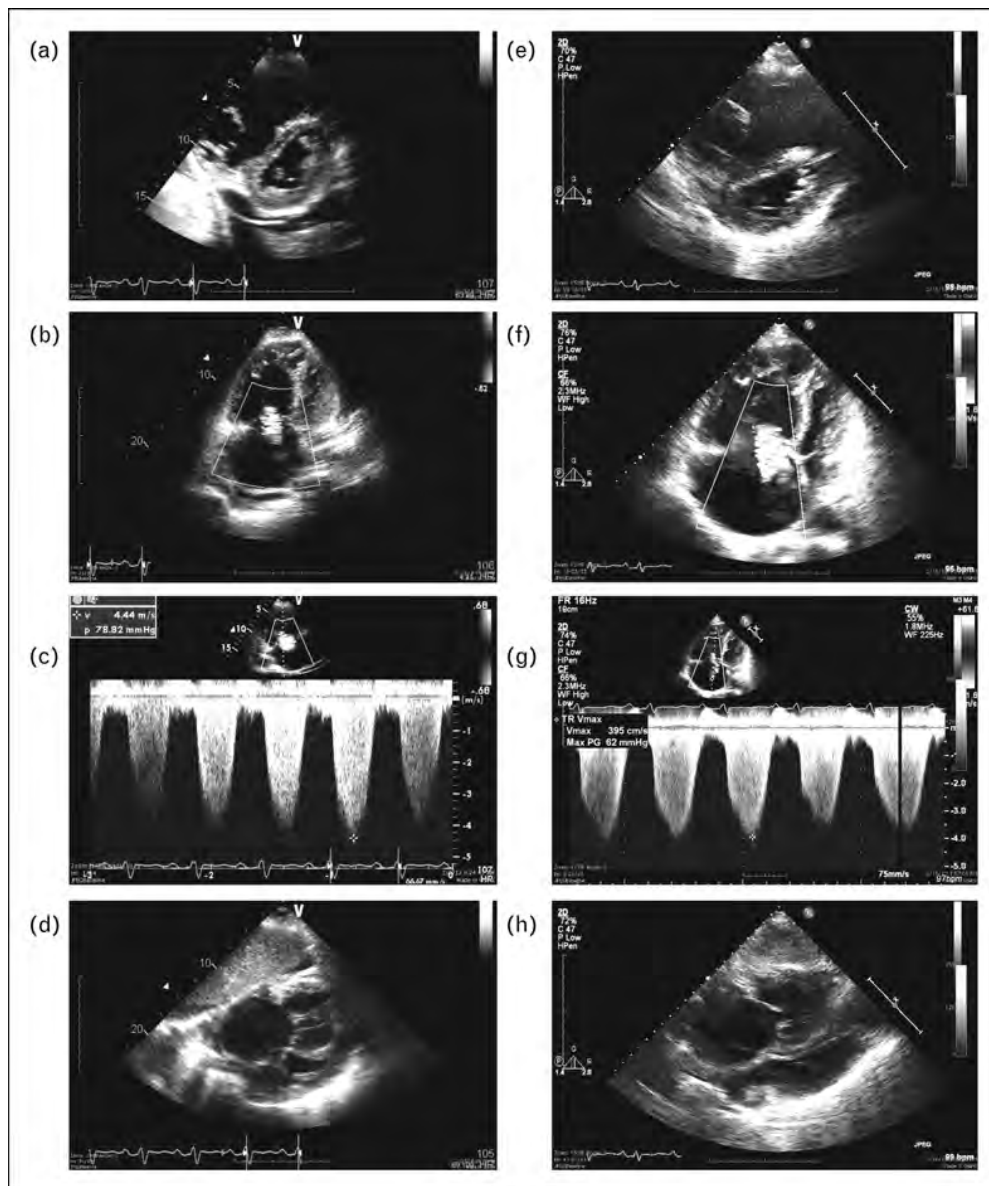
Two-dimensional echocardiographic images of a patient with chronic thromboembolic disease and severe right heart failure before (panels a–d) and after (panels e–h) optimization of volume status. The patient presented with severe weight gain, dyspnea, a 10 l/min oxygen requirement and peripheral edema. Panel a is a parasternal short-axis view of the heart, panel b is an apical four-chamber view and panel d is a subcostal view showing severe right-ventricular dilation and compression of the LV by the interventricular septum. Moderate tricuspid regurgitation (panels b and c) revealed a right-ventricular pressure of 78 mmHg plus right atrial pressure (which was estimated to be 20 cm by examination of the jugular veins). After 2 weeks of diuretic therapy, the patient lost 20 kg of weight, he was ambulating with minimal dyspnea, he required only 2 l/min oxygen, and his peripheral edema had resolved. Unexpectedly, repeat echocardiography (panels e–h) showed no significant change in right-ventricular dilation or compression of the LV despite modestly lower right-ventricular pressure (62 mmHg plus an estimated right atrial pressure of 8 cm by examination of the jugular veins). LV, left ventricle.
